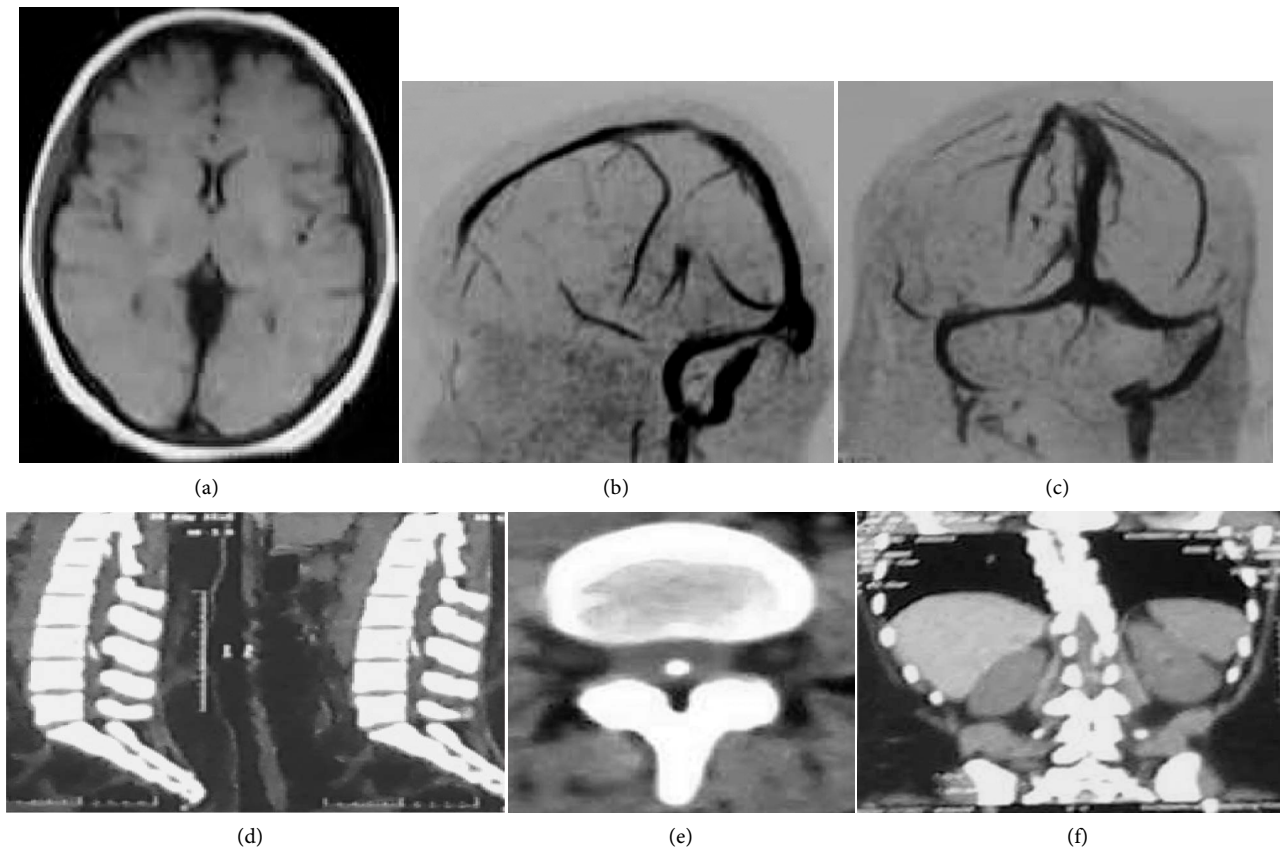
Female patient with lumboperitoneal shunt and subcutaneous abdominal wound collection, (a) T1 weighted image axial MRI showed slit ventricle, (b) and (c) Magnetic resonance venography of the patient with apparent stenosis or thrombosis, (d) CT lumbosacral spine with sagittal reconstruction showed the intra-thecal location of the catheter, (e) CT Lumbar spine, axial view showed the location of the proximal catheter, (f) CT abdomen showed the intraperitoneal location of the distal catheter.
